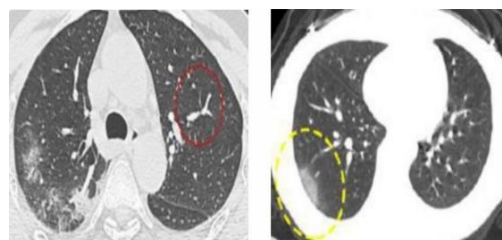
Sample Covid CT Scan Images
